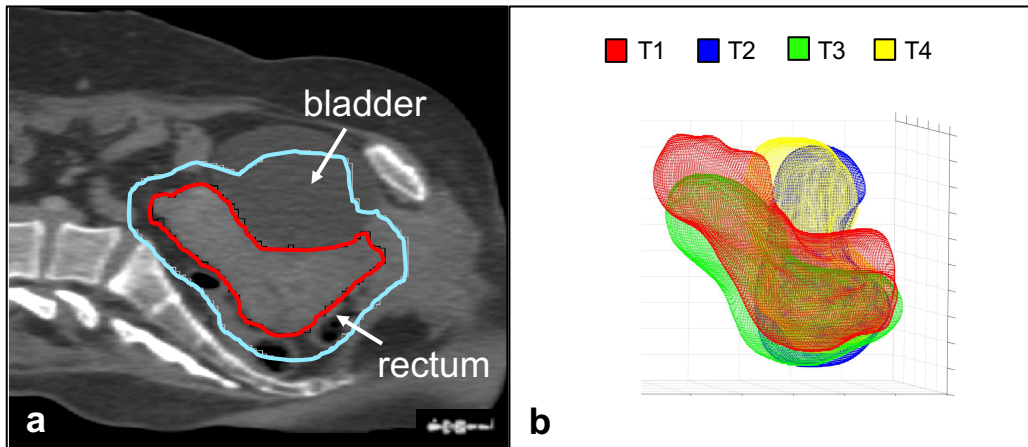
(a) Pretreatment planning CT image of a cervical cancer patient with the CTV outlined in red, and the PTV outlined in cyan. Note that large portions of healthy tissues such as the bladder and rectum are included in the PTV. (b) Superimposition of 3D uterine contours of the cervical cancer patient in (a) derived from ultrasound images taken at four different time points (T1 - T4) over the course of RT treatment. Note the large amount of day-to-day motion and deformation of the uterus over the course of RT treatment.
